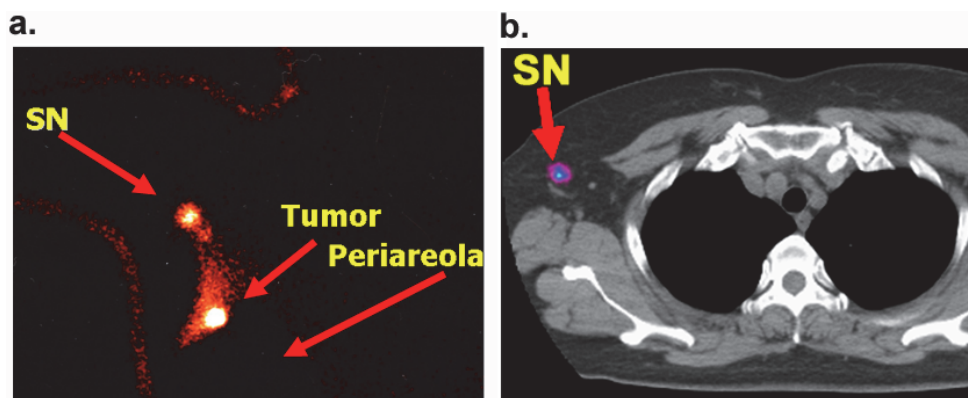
Lymphoscintigraphy and SPECT-CT
